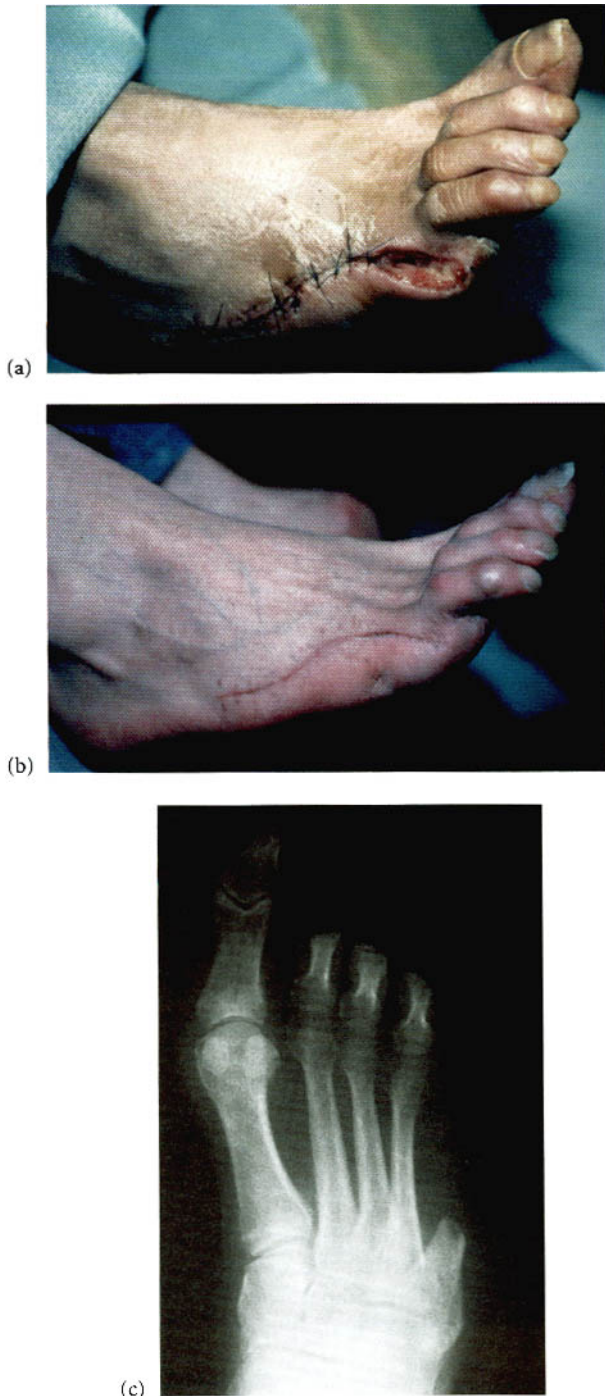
Fifth ray amputation. (a) Partial amputation of the right 5th ray. The distal portion of the wound was left open. (b) Appearance of the right foot healed after delayed wound closure. (c) Anteroposterior radiograph reveals resection of the distal two-thirds of the 5th metatarsal.
